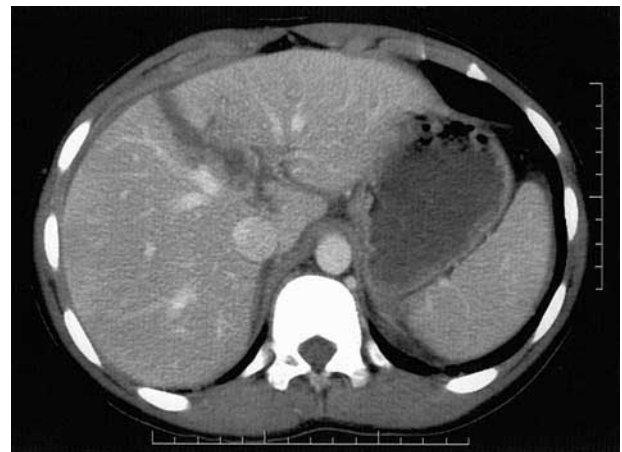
Initial CT (day 0) shows large liver laceration extending to the porta hepatis.
